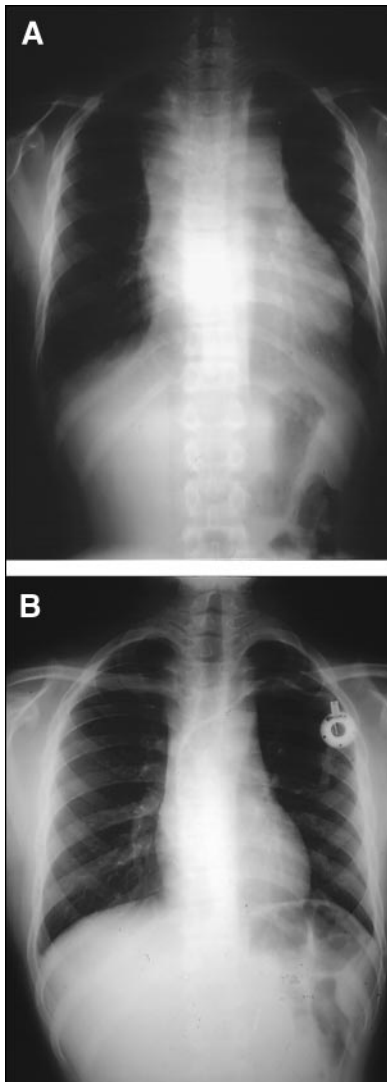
Patient *A* presented with symptoms of respiratory distress of 5 days' duration. Chest radiography revealed a large mediastinal mass with airway obstruction and enlarged cardiac silhouette consistent with pericardial effusion (A). Tissue biopsy confirmed the diagnosis of NHL (T-cell). This case exemplifies the relative short duration of symptoms due to the rapid growth associated with NHL. After 4 weeks of treatment, the patient's chest radiograph demonstrated marked decrease in the size of the mass (B).
